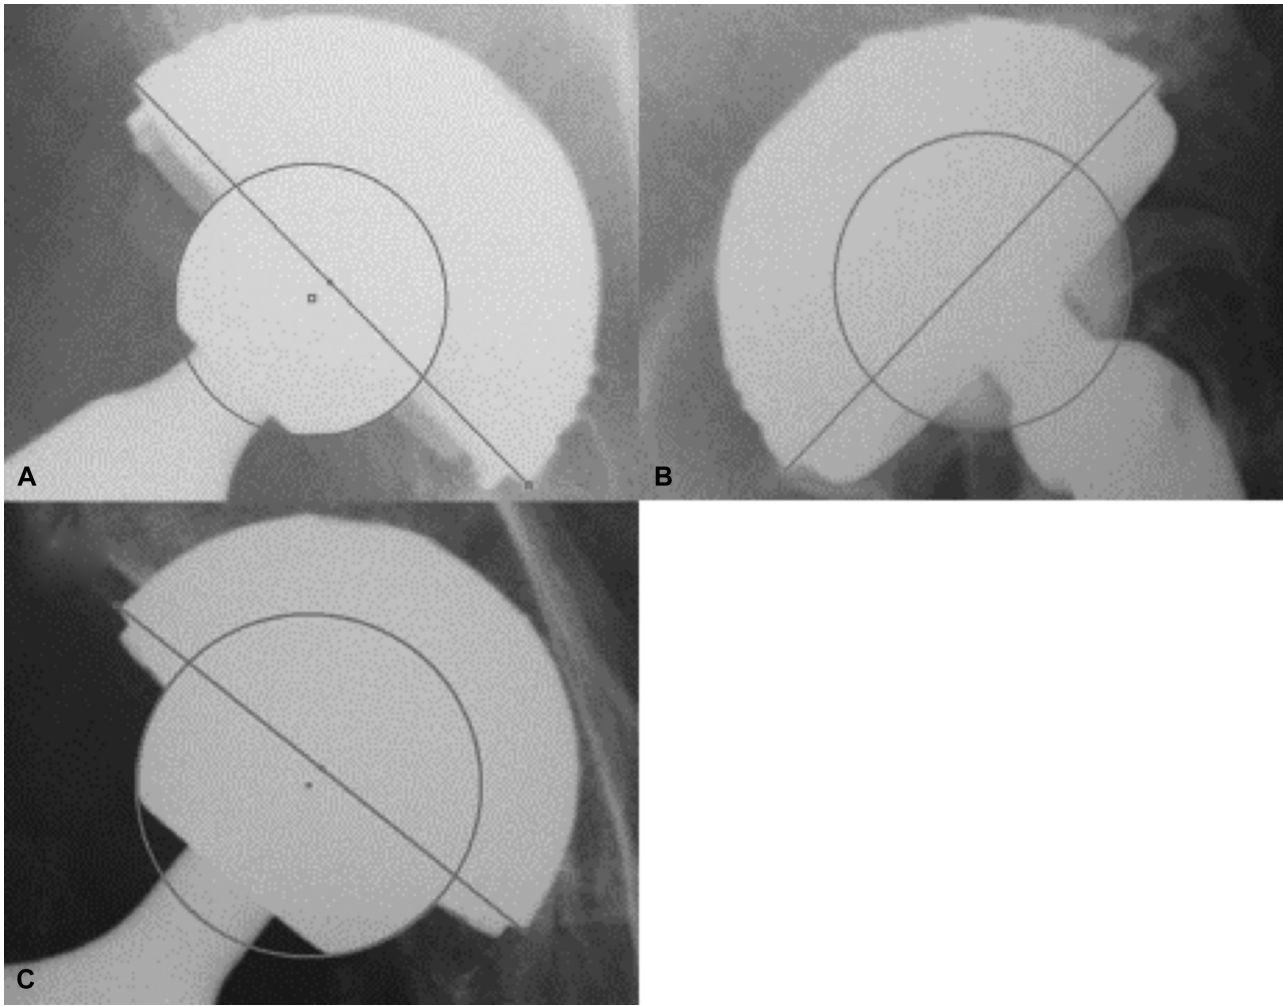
Digitized anteroposterior view radiographs using the computer-digitizer facilities of the Roman software, Version 1.70 (Institute of Orthopaedics, Oswestry, UK) were obtained to determine femoral head penetration into the liners. (A) Metal on highly cross-linked polyethylene bearing. (B) Ceramic-on-ceramic bearing. (C) Metal-on-metal bearing.
